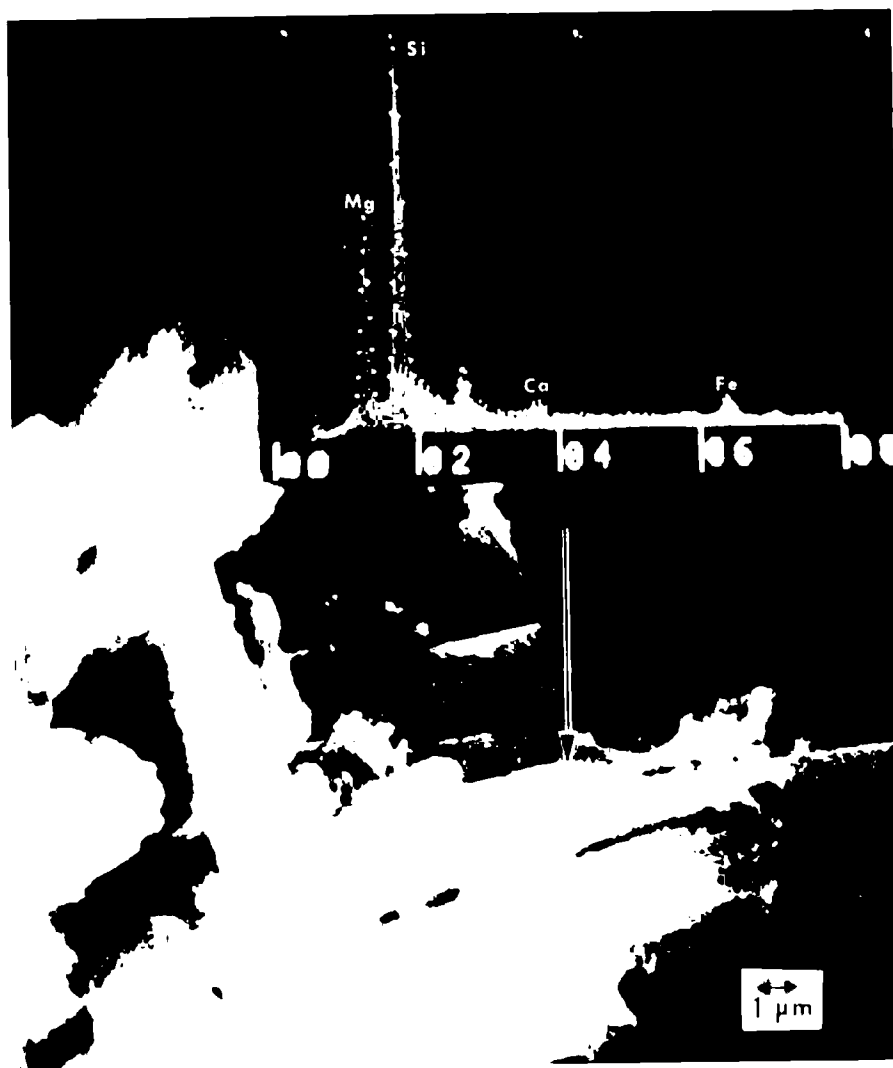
Dispersive X-ray analysis of single fiber component (arrow) of asbestos casting ring liner.
